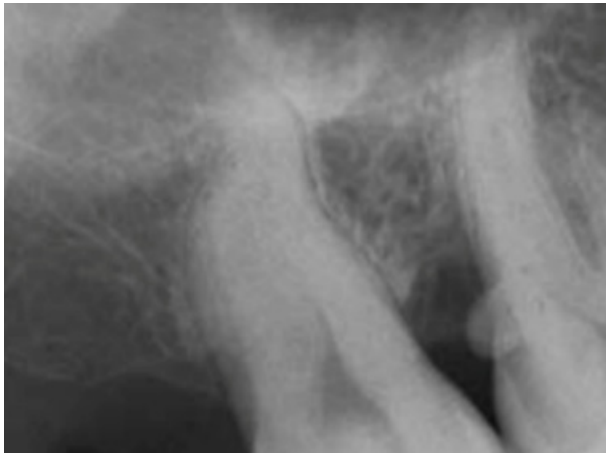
Radiographic presentation of an enamel pearl on a maxillary second molar resulting from periodontal destruction Matthews & Tabesh, 2004⁶
